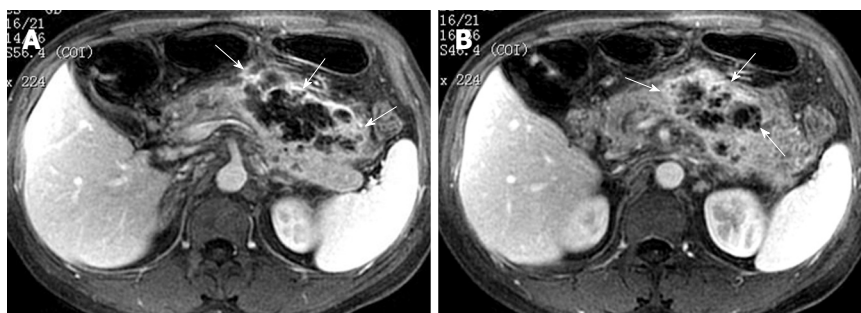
39-year-old man with acute necrotizing pancreatitis and peripancreatic cellulitis. Contrast-enhanced T1-weighted images show a ring-like and separated enhancing mass in pancreatic adjacent retroperitoneal space (arrows, A and B).
